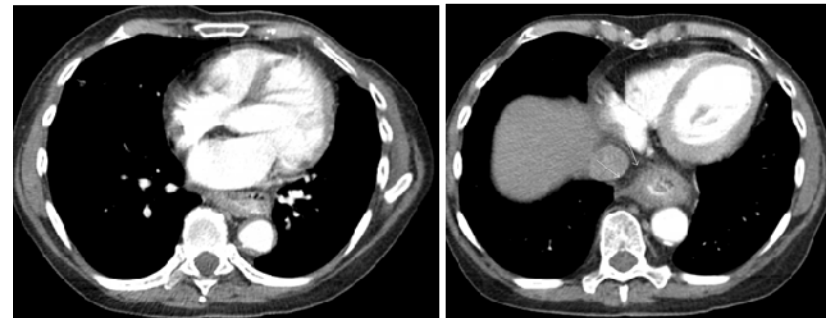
Two axial IV and oral contrast enhanced CT slices of esophageal cancer patient. Image on left is cephalad, and esophageal wall looks normal; a bit of contrast is visible in canal. Image on right shows thickened esophageal wall, but canal is still widely patent. Small arrows point at area of suspected infiltration into fat, but there appears to be clear fat between this infiltration and vena cava. In this direction, a clear margin is likely despite extra-esophageal extension. There does not appear to be a fat plane between esophageal tumor and anterior wall of aorta, suggesting that an attempt to resect tumor (without neoadjuvant treatment) may leave tumor cells on the aorta (R1). Images courtesy of the University of Massachusetts Medical School, Department of Radiology.
